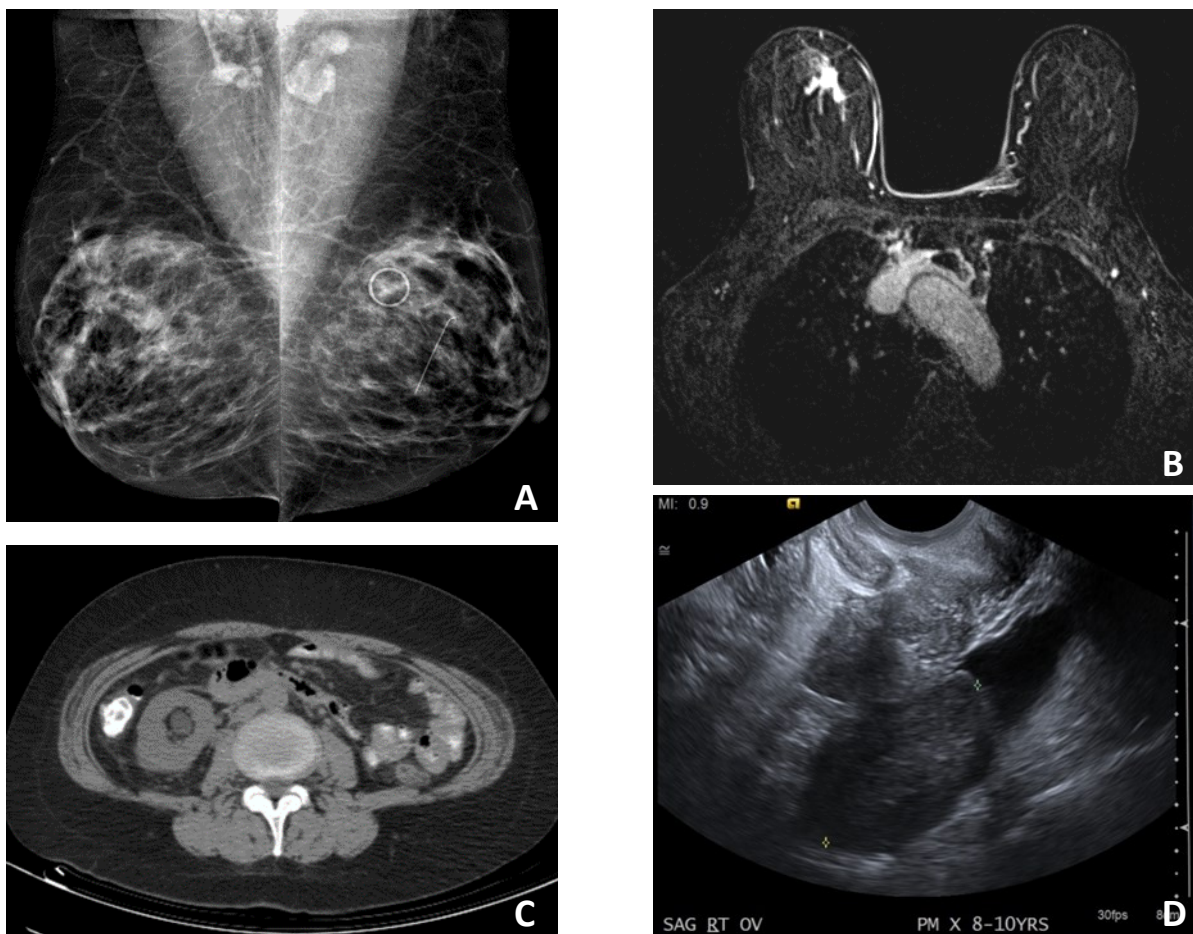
Bilateral MLO views (A) demonstrate an area of architectural distortion in the right breast at 12 o'clock with associated nipple retraction and a morphologically abnormal right axillary lymph node. Subsequent targeted ultrasound demonstrated an irregular antiparallel mass with spiculated margins (images not shown). Axial T1 post-contrast subtracted breast MRI image (B) reveals an irregular-shaped enhancing mass, corresponding to the mass seen on mammography and US. Also seen is stranding in the anterior mediastinal soft tissues as well. Unfused axial CT image from the patient's staging PET-CT exam (C) demonstrates unilateral right hydronephrosis and subtle right retroperitoneal fat stranding. Enlarged FDG avid ovaries were noted on the PET CT spurring evaluation with transvaginal ultrasound. A representative image from the transvaginal ultrasound is provided (D), demonstrating a rind of hypoechoic soft tissue encasing the ovaries.
